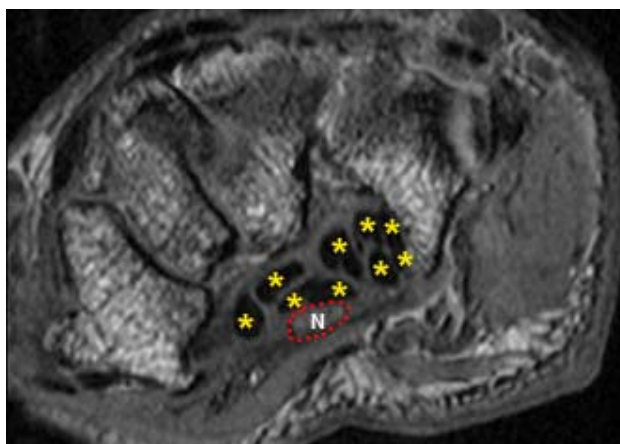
MR image through the carpal tunnel. Dark tendons are indicated with yellow asterisks and the nerve (N) is outlined by a red dotted line.
